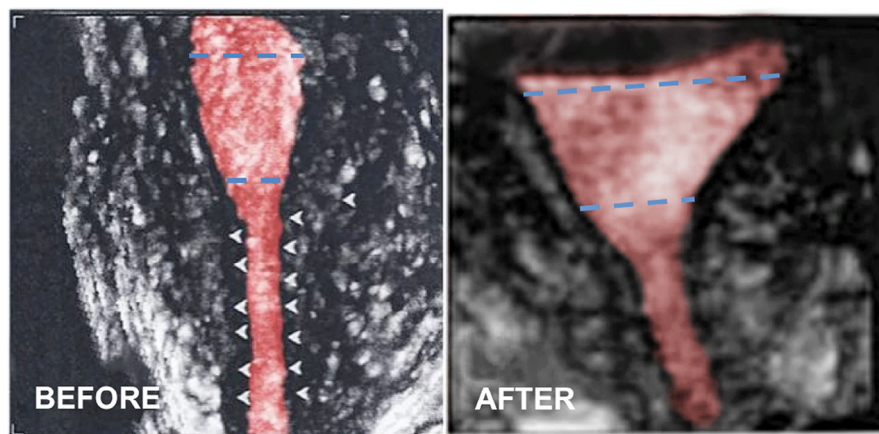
Three-dimensional transvaginal ultrasound showing the improvement of the volume and morphology of tubular-shaped uteri before and after the HOME-DU technique. A significant I/IO ratio decrease was noted. HOME-DU = Hysteroscopic Outpatient Metroplasty to Expand Dysmorphic Uteri; I = isthmic diameter; IO = interstitial distance.
